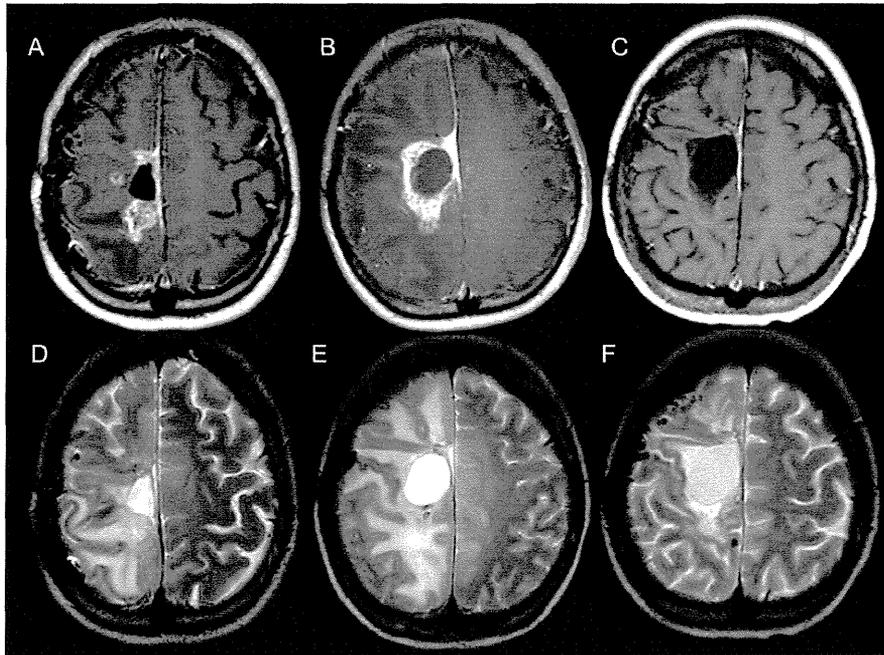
Periodic MRI changes in case 2. (A–C) Gd-enhanced T1-weighted MRI. (D–F) T2-weighted MRI. (A and D) Just prior to BNCT; (B and E) 2 months after BNCT; (C and F) 6 months after BNCT (4 cycles after initial bevacizumab treatment).
